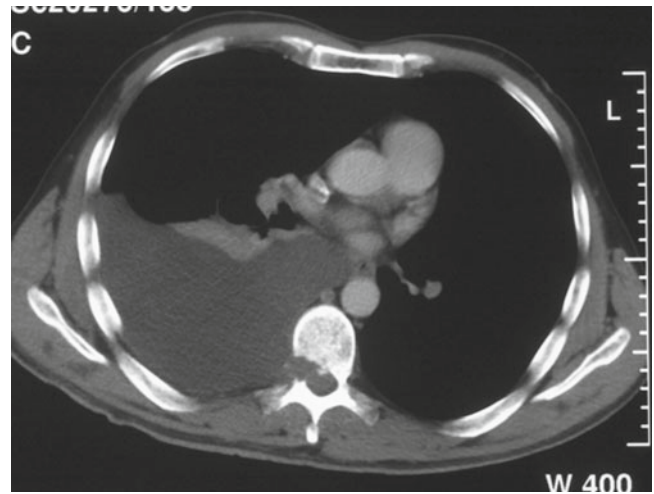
A 44-year-old man had T7/8 discectomy and developed a postoperative pleural effusion, which on CT scan was continuous with the subarachnoid space. The fluid was positive for beta-2 transferrin, confirming the fluid originated from cerebrospinal fluid (Adapted with permission from Menzies SM and Griffiths SJ, *Int Pleural Newslr* 2008; 6:19)
